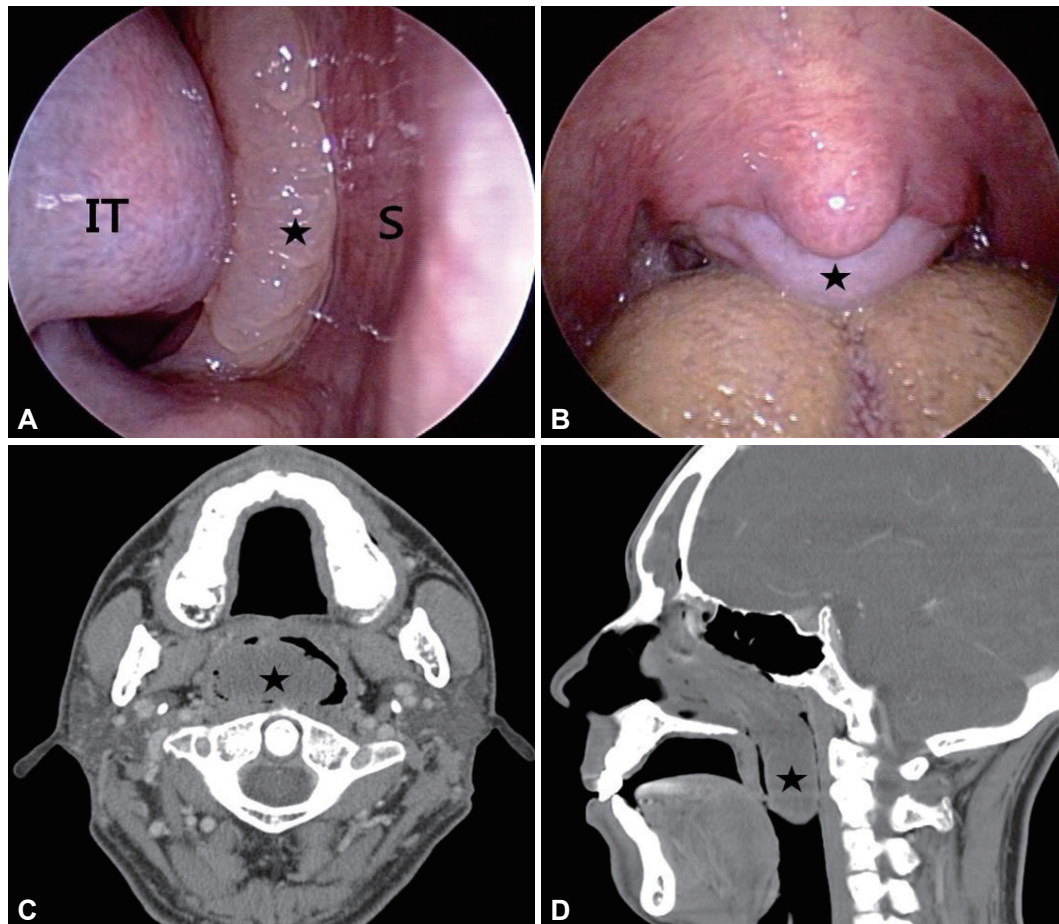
Nasal mass presenting as severe obstructive sleep apnea syndrome (Case 2). Right anterior nasal (A) and oral (B) endoscopic findings and axial (C) and sagittal (D) views of computed tomography showed a large mass occupying the naso and oropharynx. IT: inferior turbinate, S: septum, black asterisk (★): nasal mass.
